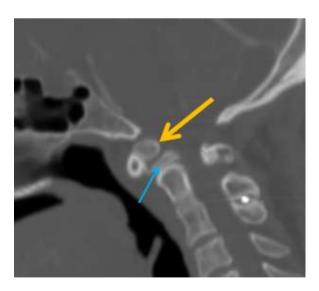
Ossiculum terminale. CT sagittal section showing os odontoideum (blue arrow) with ossiculum terminale (yellow arrow).
